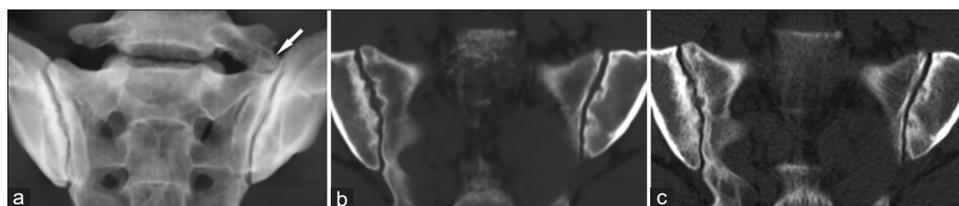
Images of a 30-year-old male with sacroiliitis. (a) The tilted “radiograph-like” image synthesized using bone magnetic resonance imaging provides an overview of the sacroiliac joints. Partial sacralization of L5 is clearly demonstrated (arrow). Osseous aspects of the sacroiliac joints and erosions are well depicted on the “CT-like” bone magnetic resonance imaging image (b). Comparing with the computed tomography image (c)
